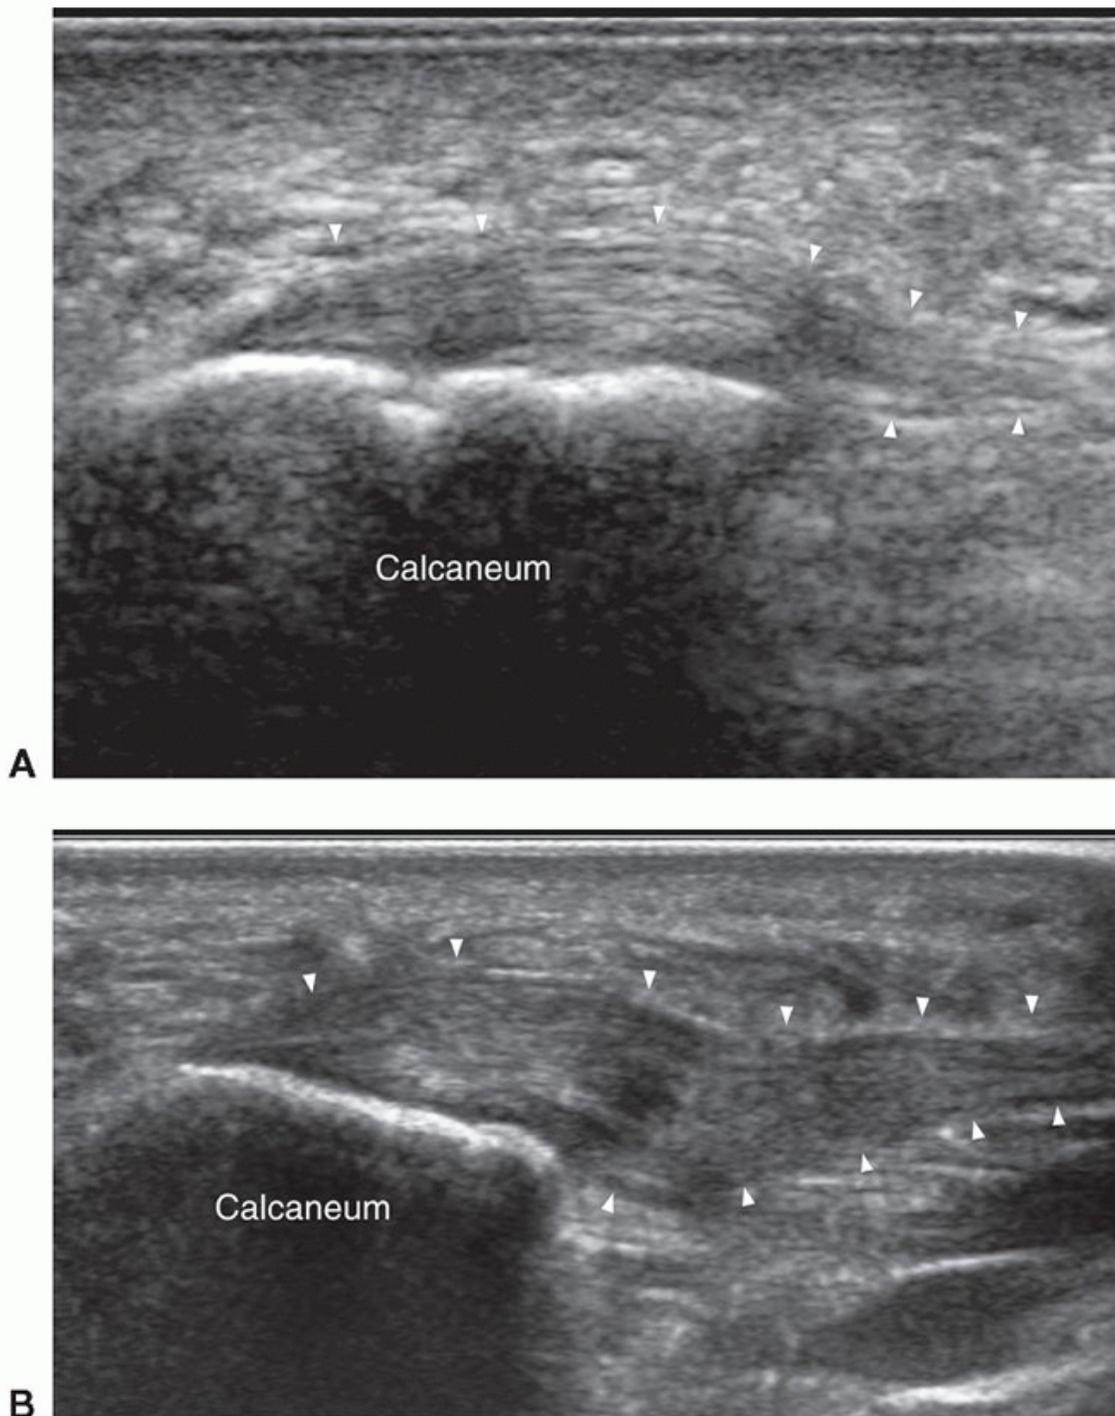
Longitudinal ultrasound of plantar heel. A: Mild (4.3 mm) thickening of the plantar fascia (arrowheads) at the leading edge of medial calcaneal tuberosity is present consistent with plantar fasciitis, although this degree of thickening can also be found in asymptomatic subjects. B: More marked (8.7 mm) thickening of the plantar fascia (arrowheads) is present, indicative of severe plantar fasciitis.
